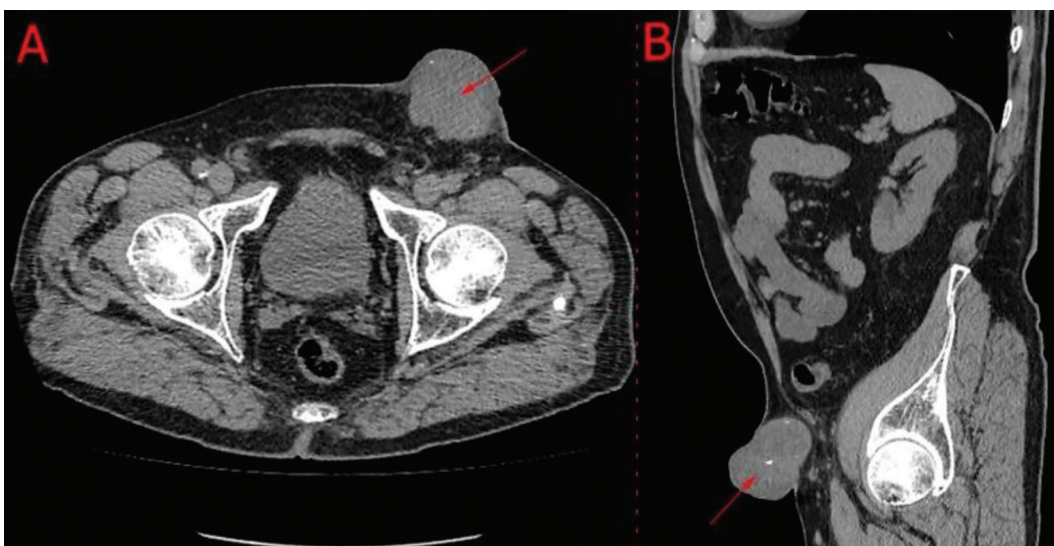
A. Abdominal CT scan, axial section (arrow indicates mass); B. Abdominal CT scan, sagittal section (arrow indicates mass).
